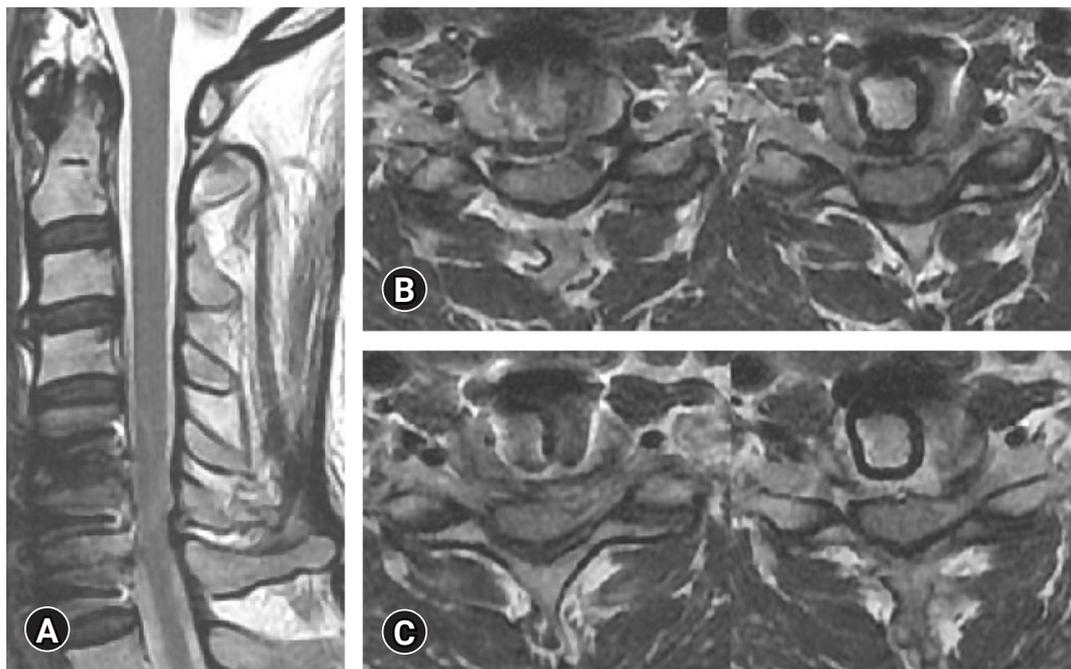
Postoperative images of the up migrated cervical disc herniation at C5-6, C6-7 level on MRI. (A) a mid-sagittal image on T2 weighted MRI. (B) Axial images at C5-6 level on T2 weighted MRI. (C) Axial images at C6-7 level on T2 weighted MRI.
